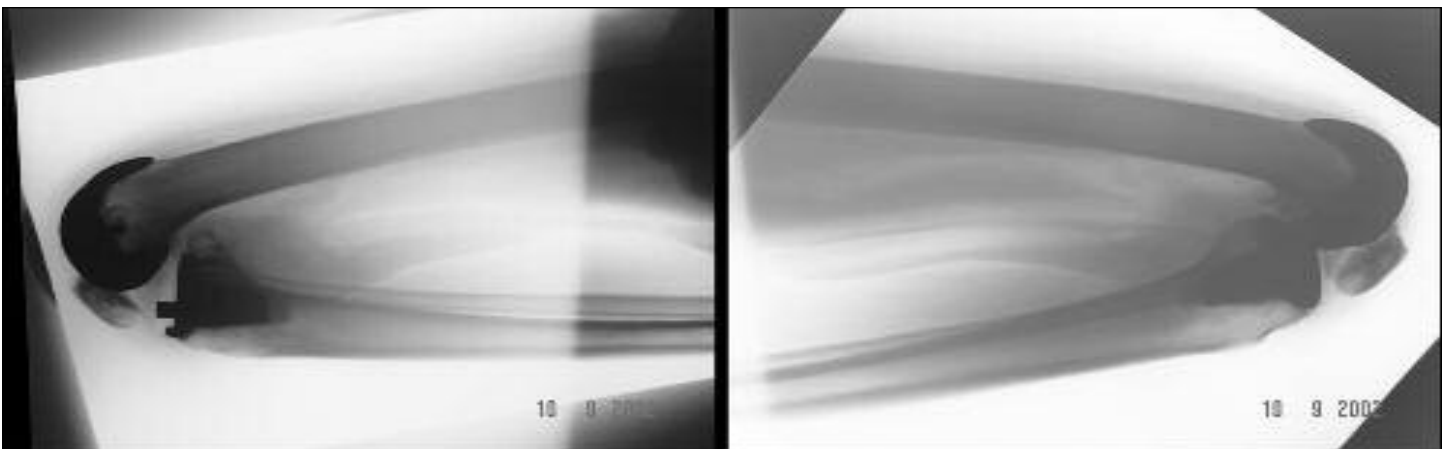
Lateral x-ray of the same patient, three months post-operatively.
